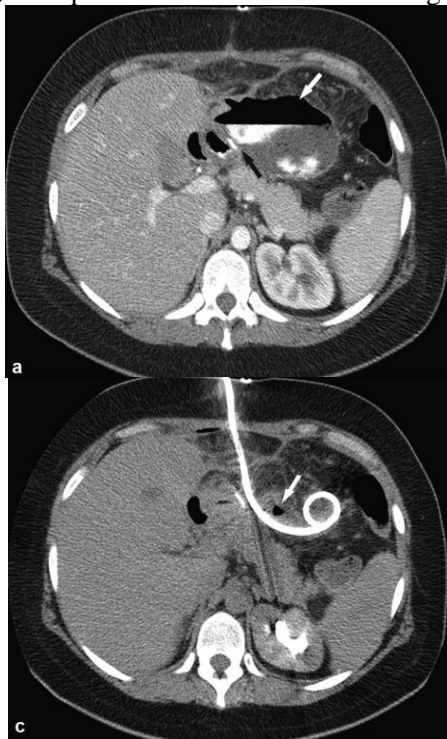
Abscess at the lower part of the staple line due to a leak. a: axial CT of the upper part of the abdomen showing a large collection with a fluid level (white arrow) containing contrast material adjacent to the staple line; b: coronal CT showing the leak between two staples and the abscess (black arrow); c: axial CT showing resolution of the abscess after drainage.
